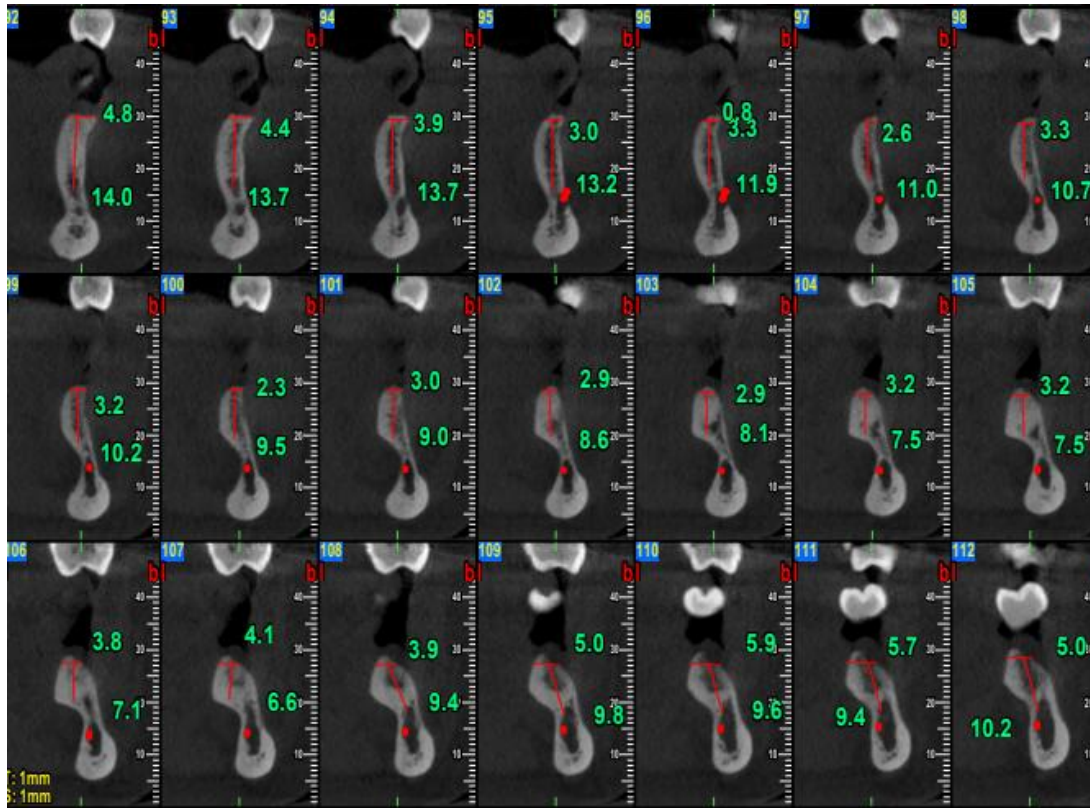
CBCT REPRESENTATION OF THE EDENTULOUS RIDGE
